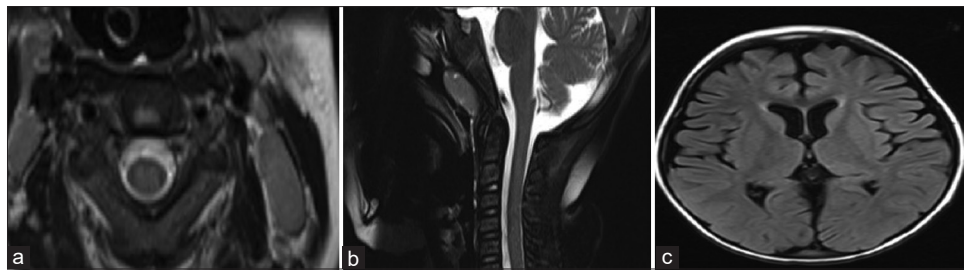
MRI findings of Patient 1. (a) Cervical T2 hyperintensity. (b) Cerebellar-cervical atrophy. (c) Cerebral atrophy
